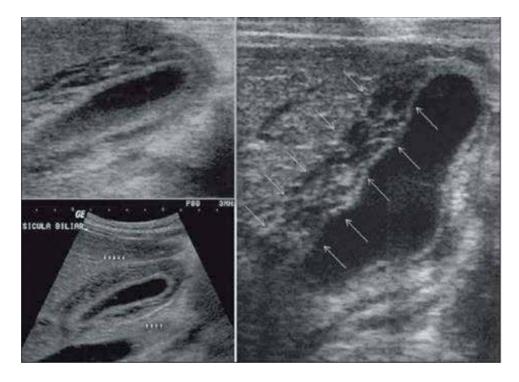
Longitudinal section of gallbladder (ultrasound view), parietal thickening with multiple echogenic layers intermingled with fluid.
